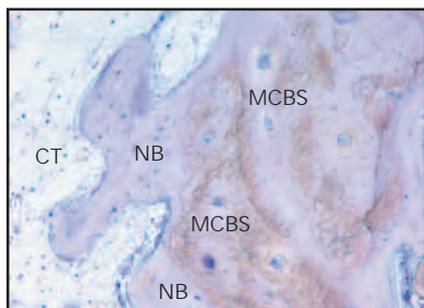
MCBS particle (Bio-Oss) with adjacent newly formed bone. NB = new bone; CT = connective tissue.
